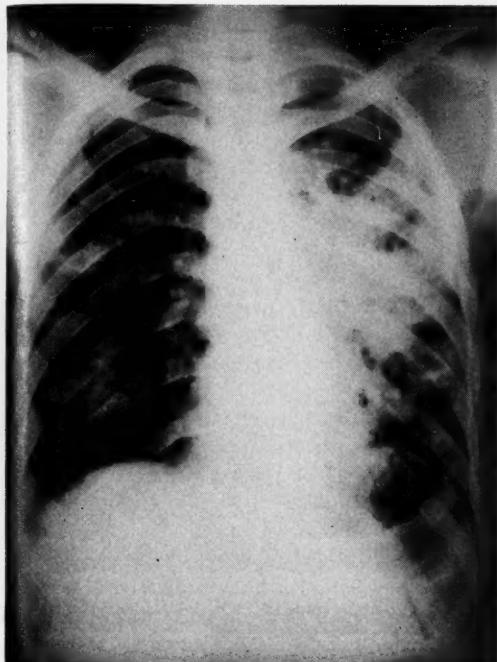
Admission x-ray of second patient described in text.
